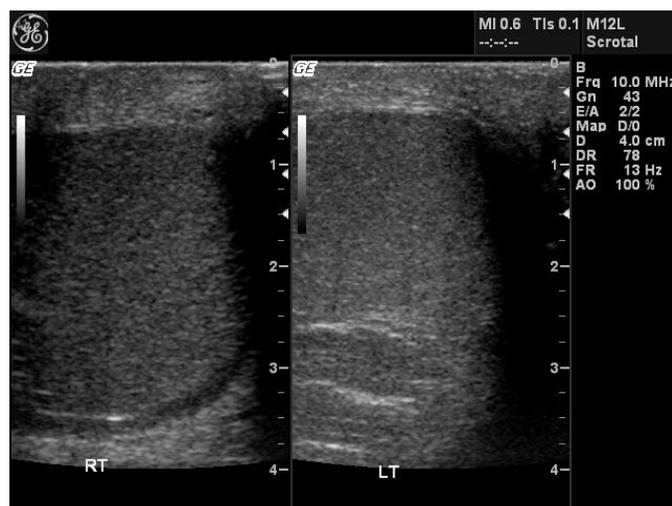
Grayscale ultrasound (transverse plane, mid testis) of the testes revealing an edematous right testis.
